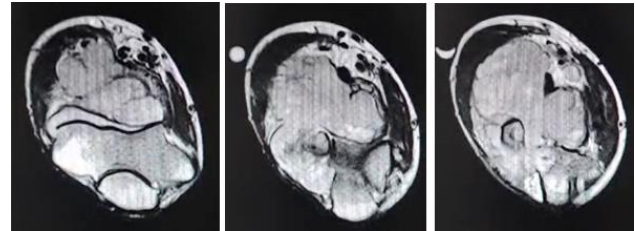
MRI in axial view at levels of supracondylar humerus, elbow, proximal radius/ulna (left to right)
